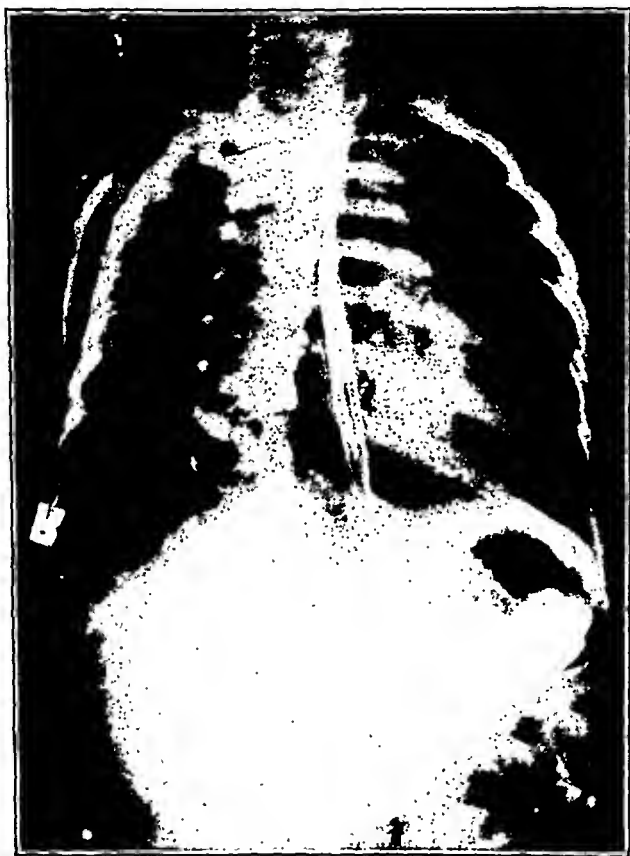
Small amount of barium given and x-ray taken approximately 2 months after rupture of lower end of esophagus.
